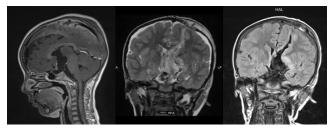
Immediate postoperative MRI scan showing near-total resection of the tumour.
